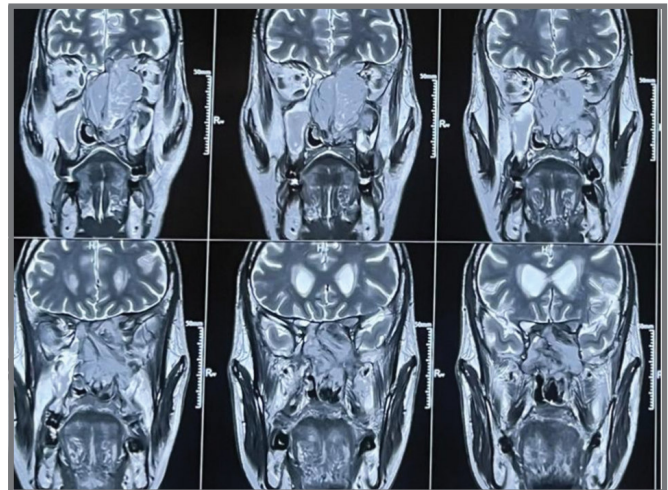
MRI PNS WITH ORBIT-2 (A) AXIAL VIEW- shows a large heterogeneously enhancing lesion eroding the nasal septum, with extension into adjacent sinuses (left frontal, maxillary, ethmoid and sphenoid) intracranial involvement (Eroding cribriform plate), and invasion of the orbit's extraconal compartment (lamina papyraceae).
